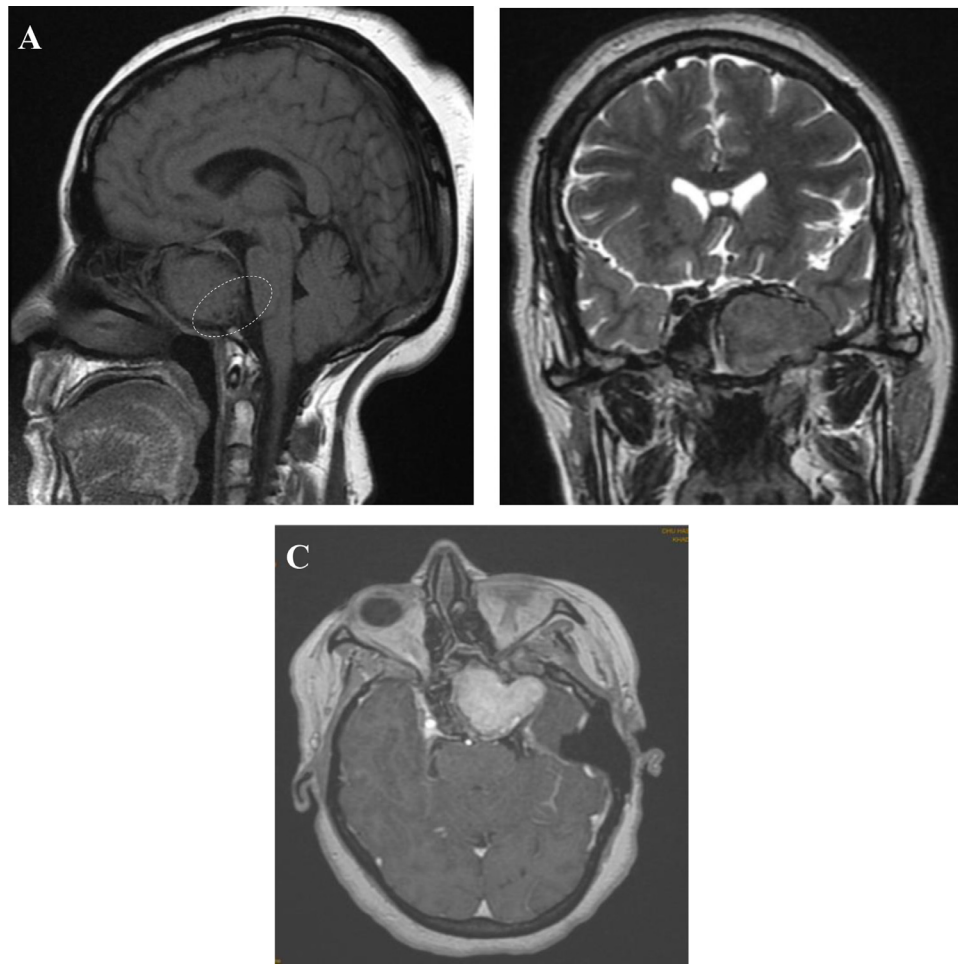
MRI scanning post 3 months denosumab treatment : A (Sagittal T1), B (Coronal T2), C (axial T1 C+) demonstrate regression in size of the sphenoid mass (white arrow), disparition of cystic component, calcified peripheral rim (circle), and increased density in both T1 and T2 WI.
